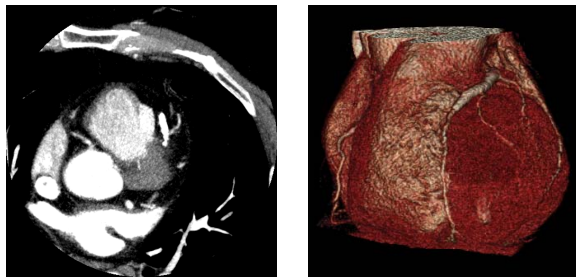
Left: Axial eight-slice MIP of coronary CTA dataset. Right: Surface rendering available on state of the art medical imaging workstations.
